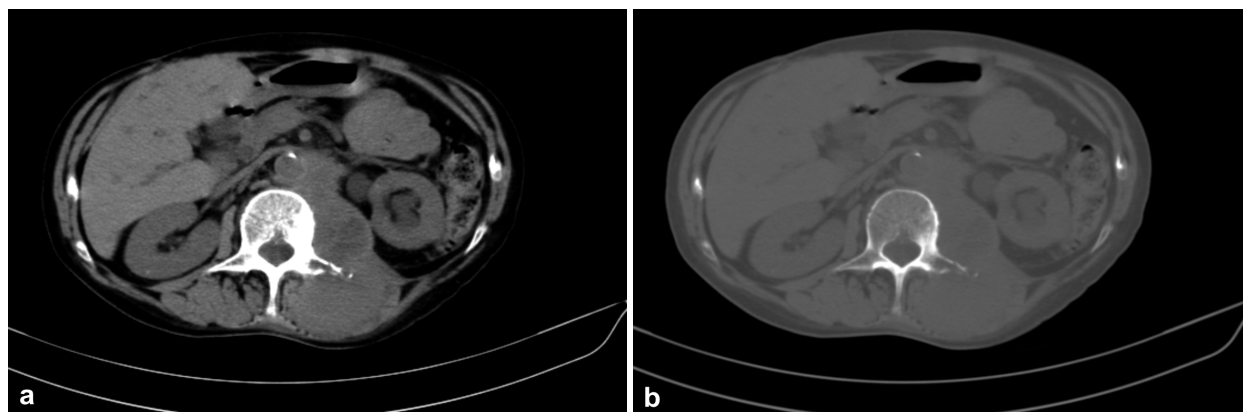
(a and b) CT axial sections, parenchymatous and bone window: osteolysis of the transverse process left L1.
